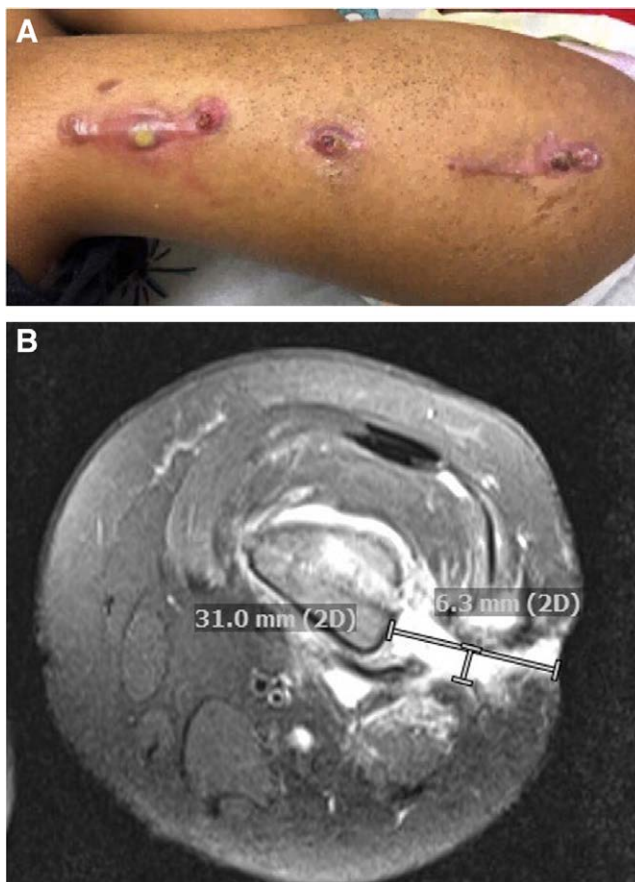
Clostridium difficile* osteomyelitis. A: Four months after being the victim of a motor vehicle accident, the patient's clinical examination was significant for 3 incisions along the left lateral thigh with a purulent collection noted at the lower incision. B: MRI 5 months following initial motor vehicle accident was significant for several thin tracts extending from the femur to the skin in addition to diffuse areas of bone marrow, adjacent soft tissue, and muscular edema as well as chronic periosteal reaction.
